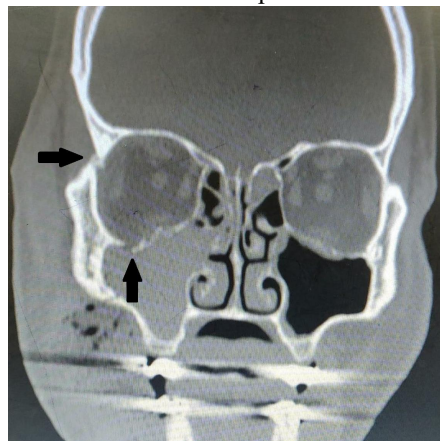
CT coronal section showing displaced fracture of frontozygomatic suture and infraorbital rim fracture
